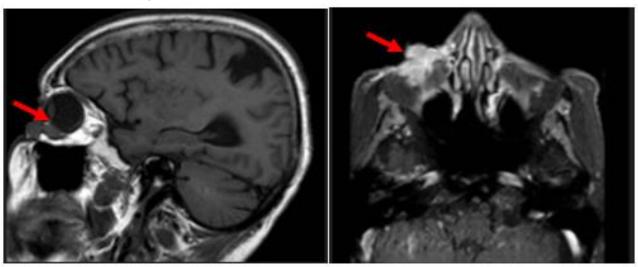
Diagnostic MRI (sagittal view and axial view)
